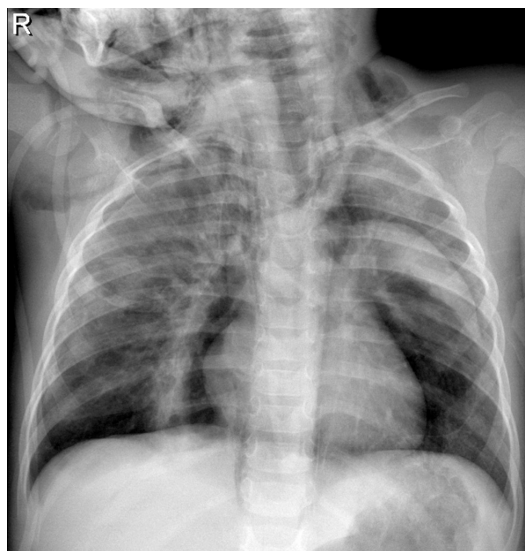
Supine chest radiograph showing left hydropneumothorax, right pneumothorax, pulmonary contusion and significant pneumomediastinum revealing the spinnaker sail sign.
